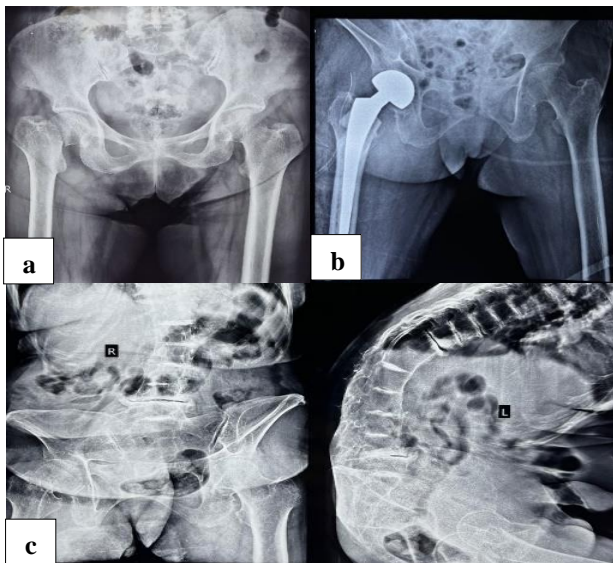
(a) Preoperative radiograph showing right transcervical neck of femur fracture; (b) postoperative radiograph showing right cemented bipolar hemiarthroplasty; and (c) radiograph of spine suggestive of intervertebral disc calcification and degenerative changes.
